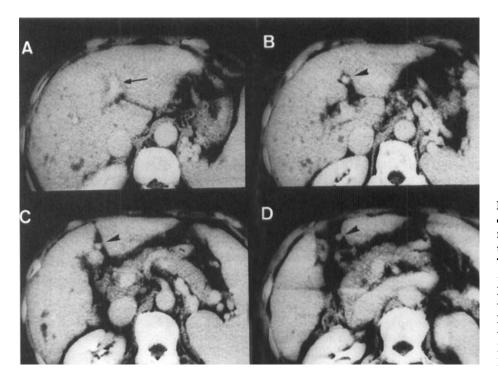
Contrast-enhanced computed tomography (CT) findings of the typical route of the para-umbilical vein. (a) The para-umbilical vein (arrowhead) arising from the left portal vein (arrow) runs through (b-d) the fissure of the ligamentum teres hepatis. The underlying disease was viral liver cirrhosis with polycystic liver.
